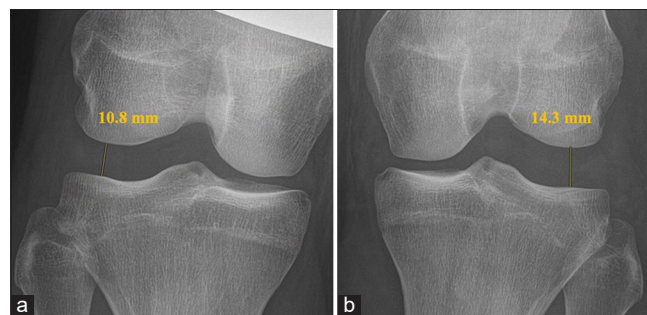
(a and b) Bilateral varus stress radiographs of the posterolateral corner (PLC). The left knee (b) exhibits 3.5 mm of additional lateral compartment separation. A side-to-side difference in varus gapping of more than 2.2 mm typically points to an isolated fibular collateral ligament tear, whereas a gap exceeding 4 mm suggests a complete rupture of the PLC.
